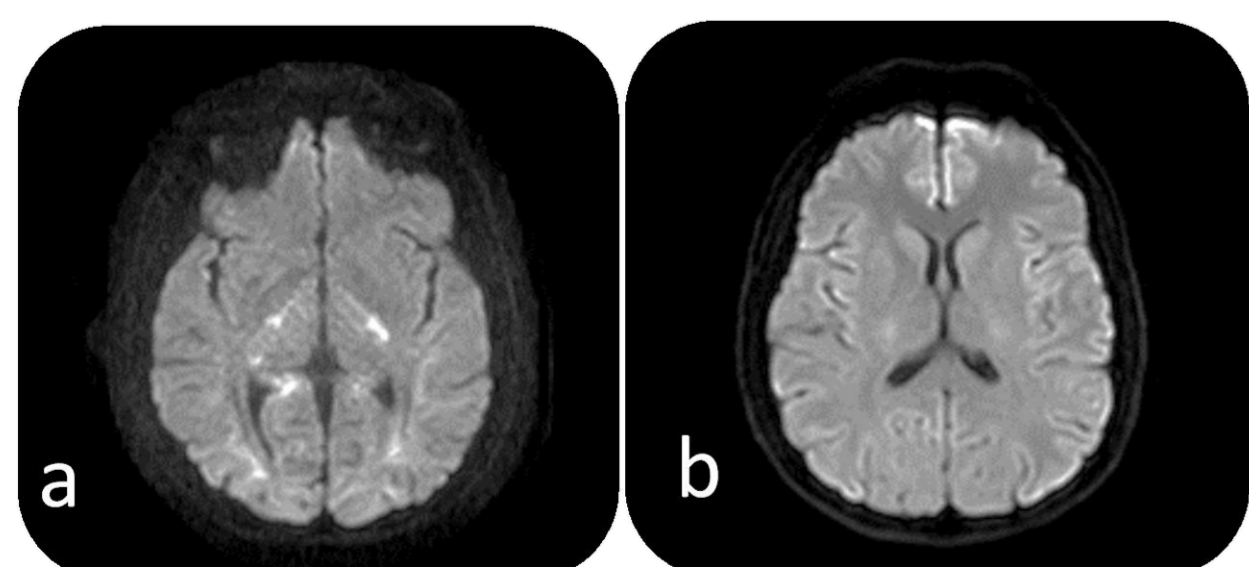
Control MRI (DWI sequence) obtained two months later demonstrated complete resolution of the imaging.
